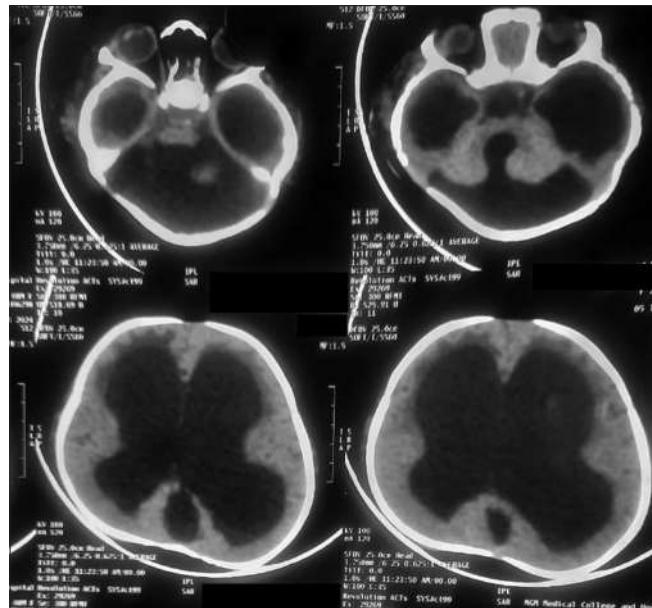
Zoomed picture of computed tomographyangiogram showing enlarged ventricle as well as hydrocephalus and postfossa defect-signify Dandy–Walker Malformation
